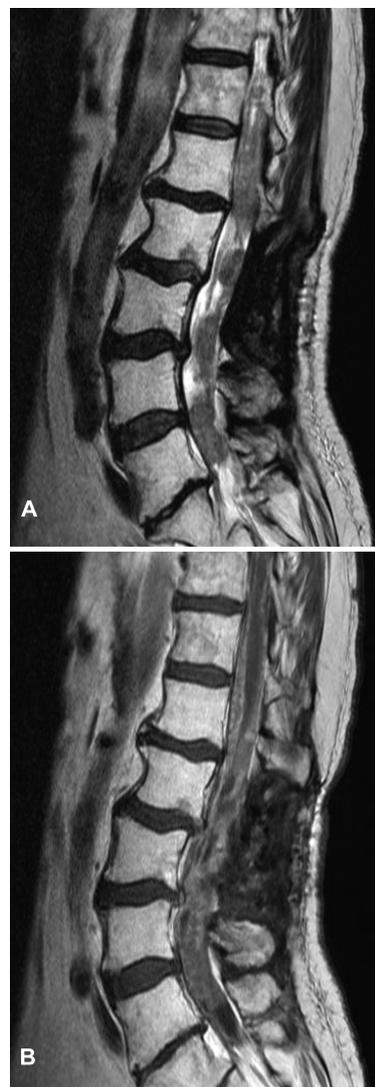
Case #1 – Lumbar MRI: Widespread spinal leptomeningeal involvement, shown on both fast-spin echo T2 (A) and T1 with gadolinium contrast enhancement (B).
